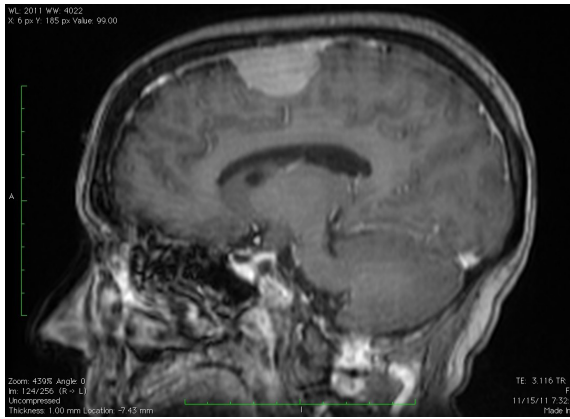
The T1-weighted MRI with contrast demonstrates a well-demarcated, dura-based and contrast-enhancing mass lesion of 4 cm in greatest dimension in the right superior frontoparietal region.
